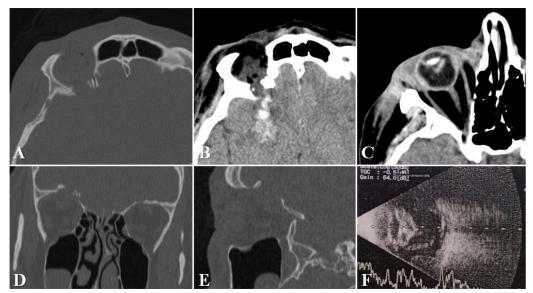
"Fracture in the right orbital roof (A, B, D, E). Vitreous hemorrhage and choroidal hematoma (right eyeball)" (C). Retinal detachment with vitreous hemorrhage and choroidal hematoma (ocular ultrasound) (F) (from *Turliuc et al., 2017*)
